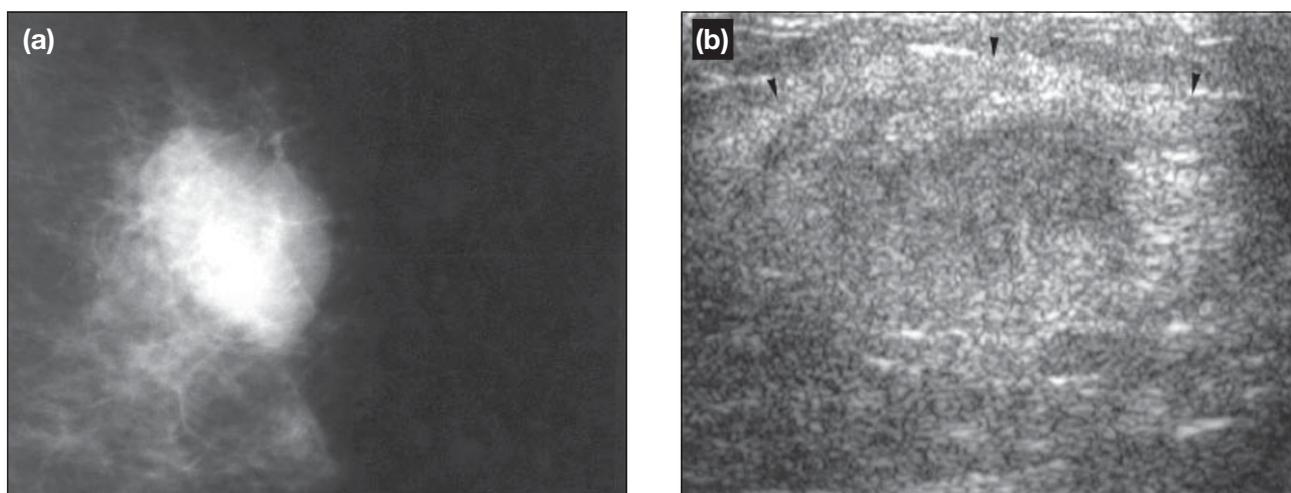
(a) Typical appearance of multiple myeloma on mammogram, presented as lobulated mass, resembling a benign lesion. (b) Ultrasound study of the same patient shows a hyperechoic mass (small black arrowheads), suggestive of multiple myeloma.
